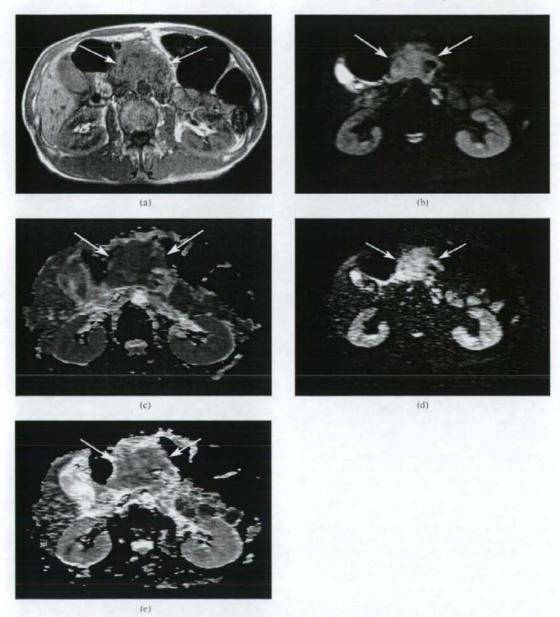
Images from a 66-year old man with relatively stable advanced pancreatic cancer. Progression was noted on the 8-month follow-up CT. (a) Transverse T_1 weighted fast-field echo image shows an irregularly shaped tumour at the pancreatic head (arrows). (b) Isotropic diffusion-weighted image and (c) the apparent diffusion coefficient (ADC) map using the middle b-value (400 s mm 2) show an inhomogeneous high-signal mass (arrows). The ADC was $1.42 \cdot 10^{-3}$ mm 2 s $^{-1}$. (d) Isotropic diffusion-weighted image and (e) the ADC map with a high b-value (1000 s mm $^{-2}$) show an inhomogeneous high-signal mass (arrows). The ADC was 1.40×10^{-3} mm 2 s $^{-1}$.
